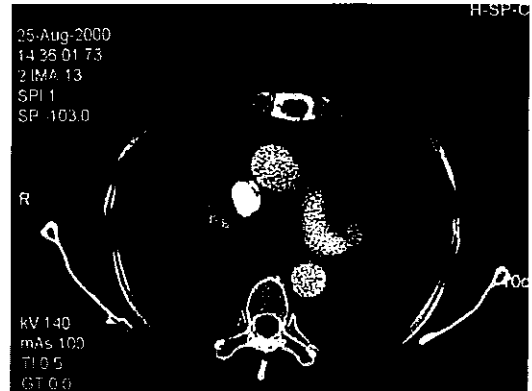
CT scan of patient who presented with myasthenia and was found to have a large, malignant thymoma.
